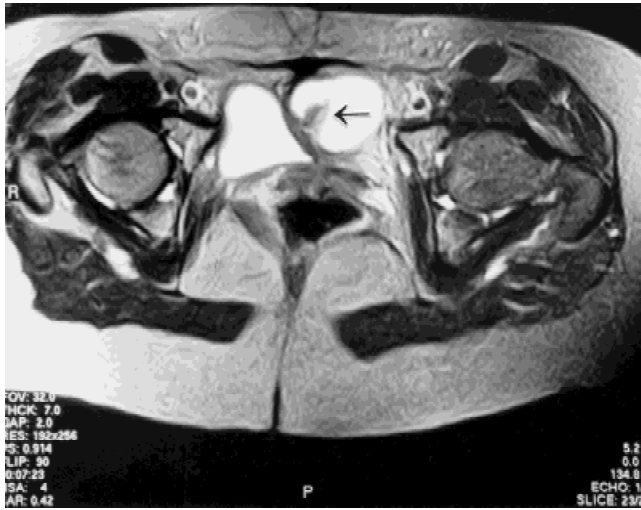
T2 weighted axial sequenced magnetic resonance image demonstrating the duplicated bladder and shared common wall. Note the nodular mass along the medial wall of the left hemibladder, which represents the primary bladder cancer (see arrow).
